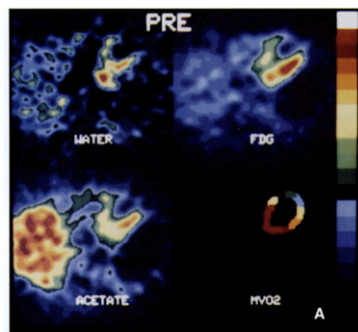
A, Tomographic reconstructions of myocardial perfusion and metabolism before (PRE) revascularization in the heart of Subject 9, who was subsequently found to have nonviable myocardium (as judged from wall motion analysis) in the anteroapical wall. The image of relative perfusion is at the upper left and that depicting relative glucose (FDG) utilization is at the upper right. The image at the lower left represents regional ^{11}C -acetate, from 3 to 8 min after the administration of ^{11}C -acetate. At the lower right is a parametric display of relative values for k_1 , reflecting regional differences in myocardial oxidative metabolism (MVO₂). White represents peak activity (or the fastest myocardial clearance of ^{11}C activity); dark blue represents lowest activity (or the slowest myocardial clearance of ^{11}C activity). In the images the septum is to the left and anterior structures are superior. Before revascularization, myocardial perfusion and utilization of glucose were reduced concordantly within the anteroapical wall compared with values in the functionally normal posterolateral wall. Myocardial oxidative metabolism within the anteroapical wall was severely depressed 30% to 40% of that in the normal posterolateral wall. B, After (POST) revascularization, regional myocardial perfusion and glucose and oxidative metabolism within the anteroapical wall remained diminished compared with values in normal myocardium.
